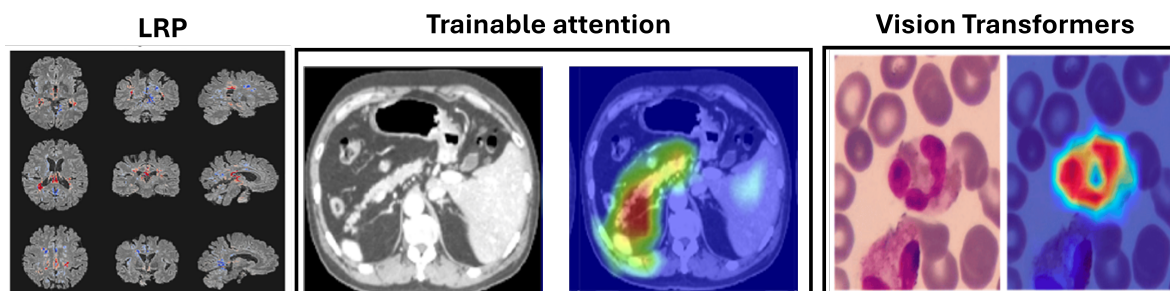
Example uses of decomposition-based attribution methods for model interpretability to show the Layerwise relevance propagation for model interpretation in diagnosing multiple sclerosis on brain MRI (Eitel et al., 2019)[160]. The Attention U-Net for organ segmentation in abdominal CT scans [161] and the areas upon which the model correctly focuses its predictions on the test images in explainable Vision Transformers model [162].
